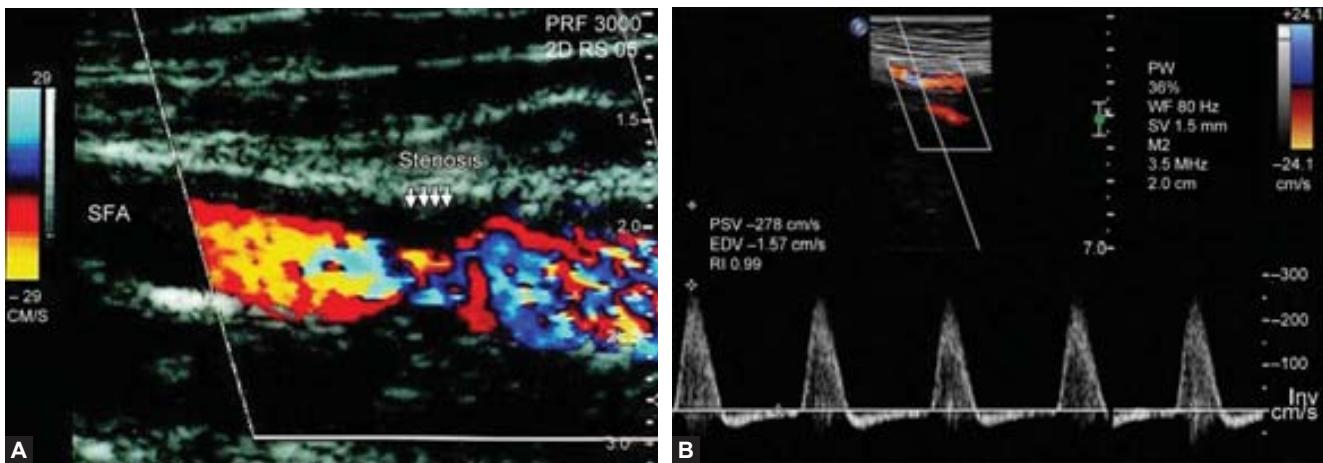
Duplex ultrasound assessment showing stenosis of superficial femoral artery.
